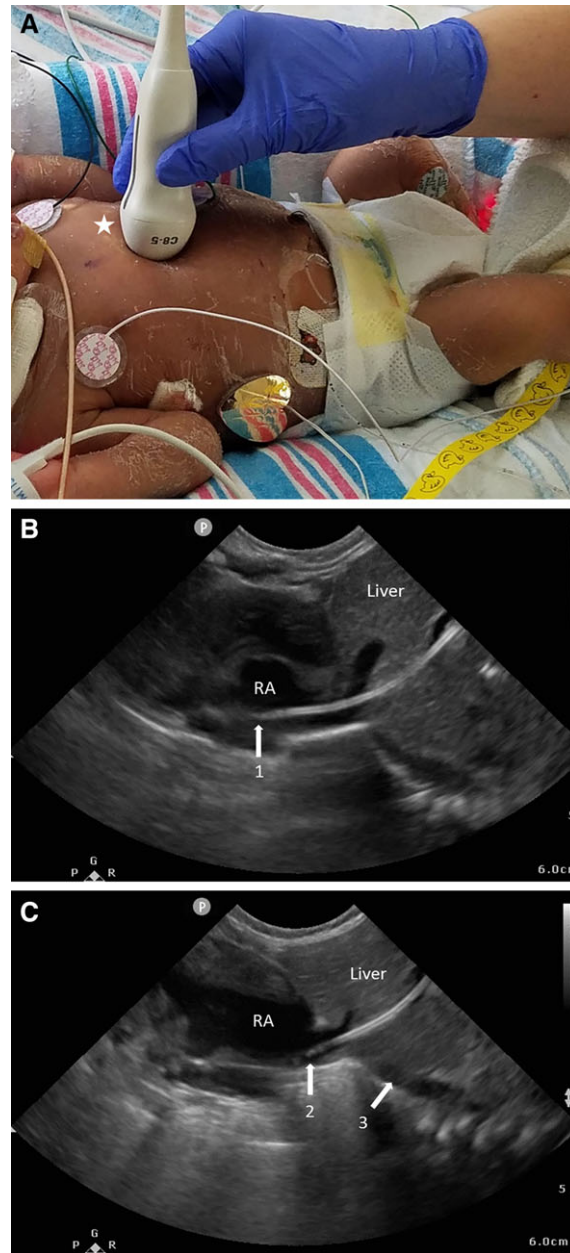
Rapid location of venous catheters. A, Probe placed in the subxiphoid position with marker (star) toward the patient's head and held at a 90-degree angle to patient's longitudinal axis. The probe is angled slightly toward the patient's right to visualize the inferior vena cava (IVC). B, Ultrasound image demonstrating the liver and right atrium (RA) with the umbilical venous catheter whose tip is deep in the RA (1). C, Ultrasound image demonstrating the liver and RA with the umbilical venous catheter whose tip has been pulled to be at the cavoatrial junction (2). Also seen is the IVC (3).
